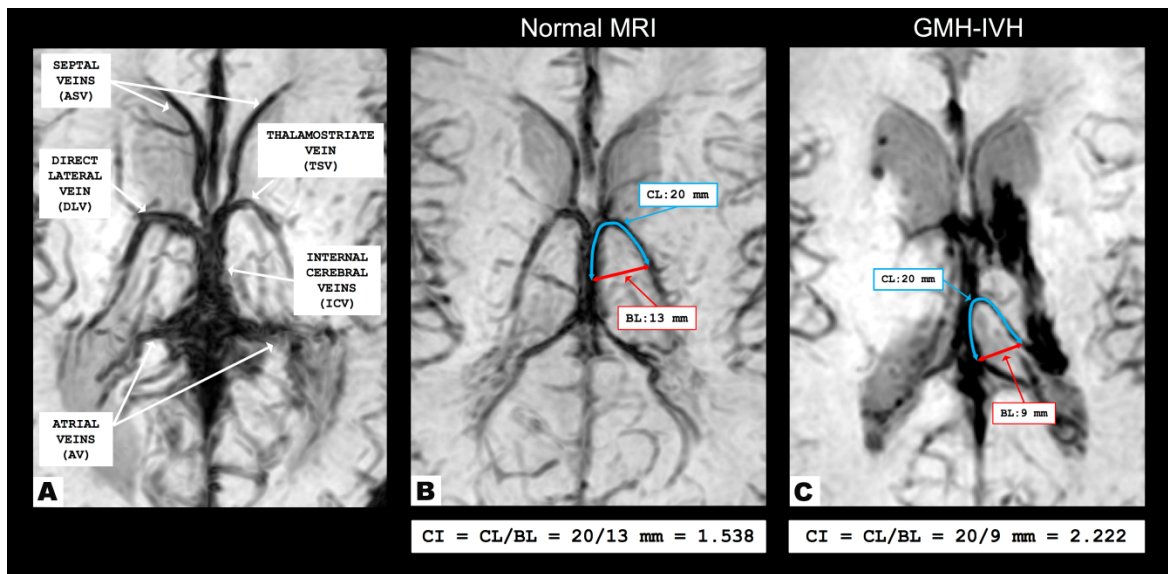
A) Representation of SV on axial-reformatted SWI-venography. B) and C) Axial-reformatted SWI-venographies in preterm neonates with normal brain MRI (CI measurement performed on TSV) and GMH-IVH (CI measurement performed on DLV), respectively. CL curve line, BL basal line, CI curvature index.
